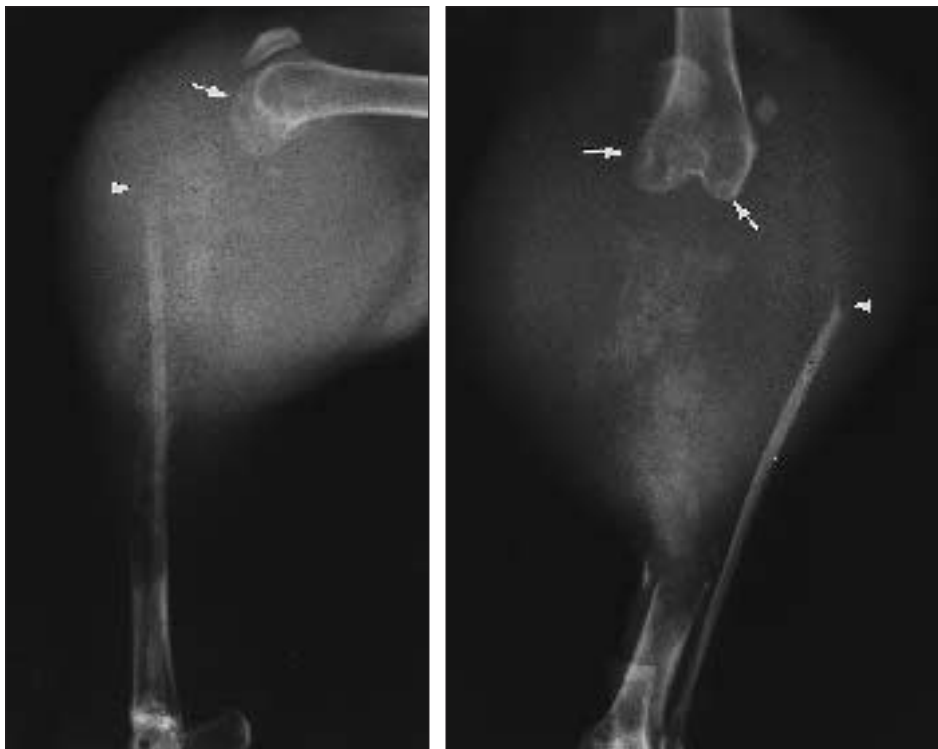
Same radiographic views as in Figure 1. Notice the severe osteolysis of the proximal two thirds of the tibia and associated soft-tissue swelling. The stifle joint is disarticulated, and the fibula is displaced cranially and laterally. Lysis of the head of the fibula (arrowheads) and radiolucencies within the femoral condyles (arrows) are also apparent.
